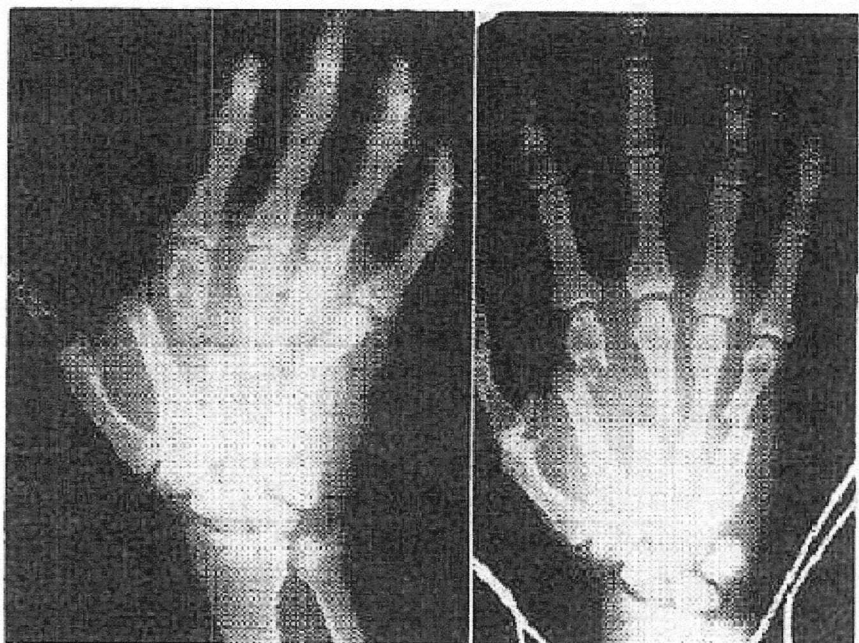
Severe hand injury with multiple compound fractures and some gas in tissues (left). Same hand a few days later after prophylactic X-ray irradiation: no gas in the tissue, no infection, hand on way to complete recovery, Kelly and Dowell[7]
